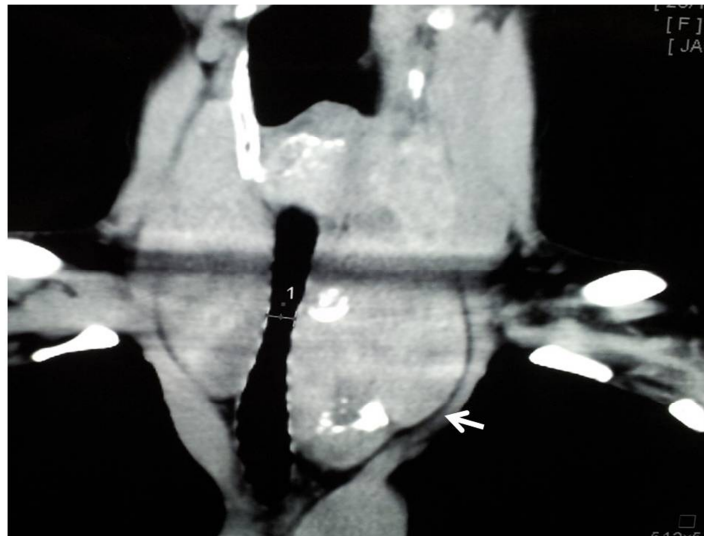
Coronal CT Showing the Retrosternal Extension of Multinodular Goitre (Arrow).
